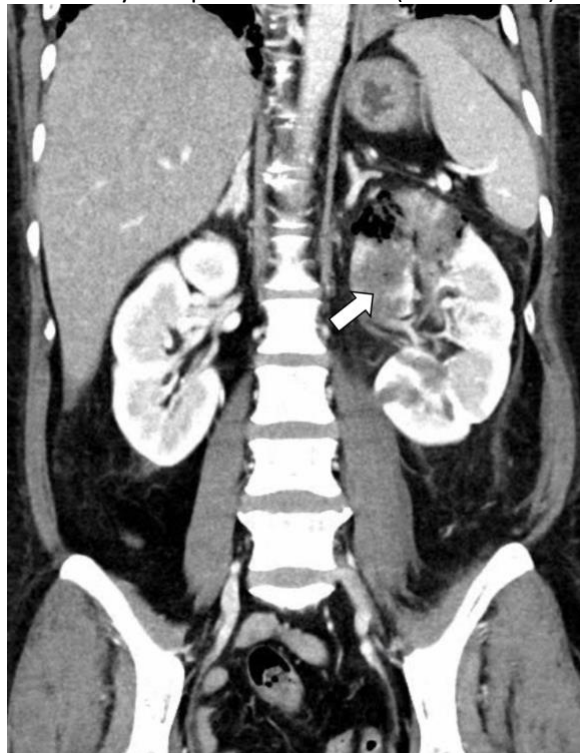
CT Abdomen & Pelvis (coronal) showing similar features at the superior pole of left kidney compatible with EPN (white arrow)
